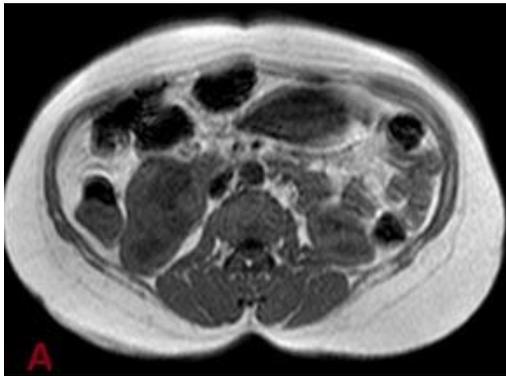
(A) axial T1WI and (B) axial T2WI Show right mid zonal solid renal lesion with small central breakdown eliciting low signal in T1, heterogeneous in T2. (C) DWI with b value 1000 and (D) ADC map show restricted diffusion. ADC value of the lesion was $1.07 \times 10^{-3} \text{mm}^2/\text{s}$.
